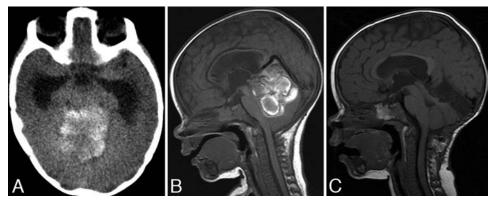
Case 1. A: Axial noncontrast CT scan demonstrating a large fourth ventricular hemorrhagic mass with obstructive hydrocephalus and brainstem compression. B: Sagittal T1-weighted noncontrast MR image demonstrating the extent of the posterior fossa mass (after ventriculostomy). C: Sagittal T1-weighted noncontrast MR image obtained 6 months after resection.
